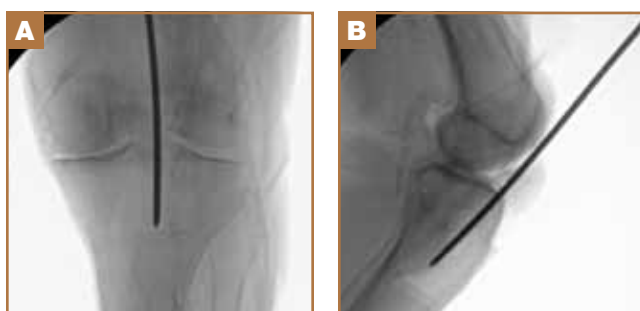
AP radiograph (A) and lateral radiograph (B) using new modified radiographic technique, with the “twin peaks” AP view, and the “flat plateau” lateral view.
